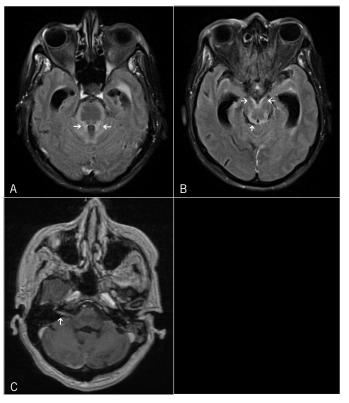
(A) Axial FLAIR MRI with striking symmetric intra-axial T2/FLAIR signal abnormalities on the surface of the brainstem, surrounding the fourth ventricle, and extending into the anterior portions of the cerebellar hemispheres. The fourth ventricle is mildly enlarged. (B) Leptomeningeal metastases involving multiple lower cranial nerves within the posterior fossa bilaterally. (C) Axial 3D multi-planar reconstruction (MPR) with enhancement of the right eighth cranial nerve demonstrating encasement by tumor.
